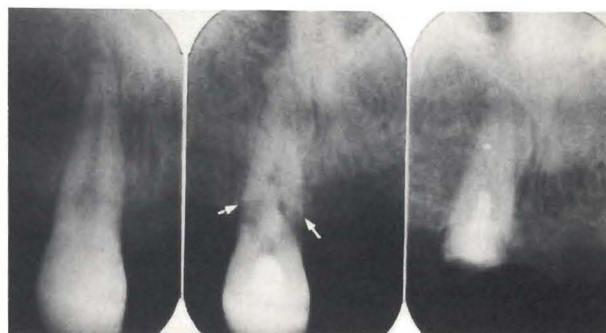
The apical radiographs of the right central incisor (tooth 11) of the same patient as in Figure 1. On the left is the restored crown following the accident. In the center, the white arrows indicate the external resorption two years after the accident and on the right is the remaining root structure with the calcium hydroxide dressing in the pulp canal.
